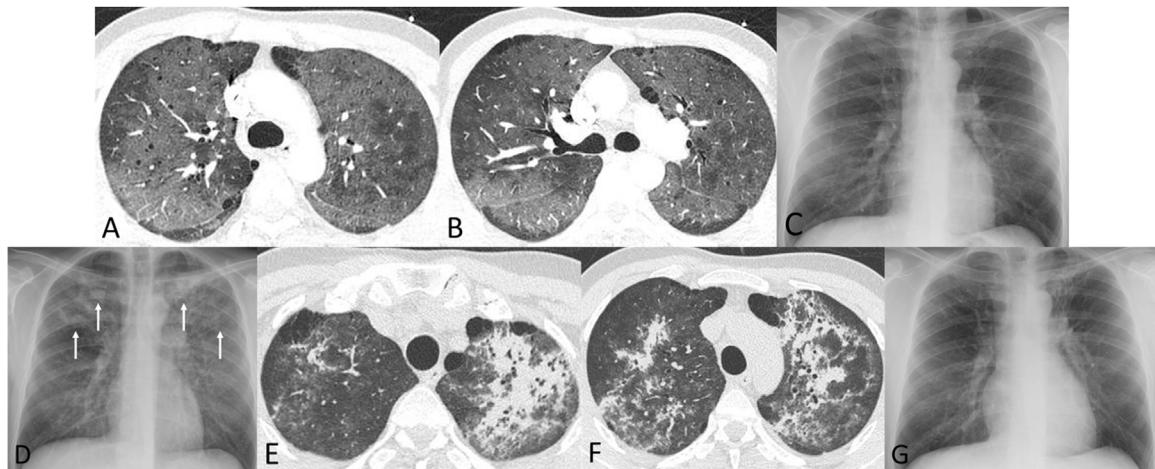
(A) and (B) Axial thoracic CT images (lung window) show extensive ground-glass opacities in both lungs, consistent with *Pneumocystis jirovecii* pneumonia. (C) Posteroanterior chest radiograph performed on the day of discharge shows resolution of opacities after treatment with cotrimoxazol and prednisolone. (D) Three days after being discharged, a repeat chest radiograph shows new-onset bilateral consolidations (arrows). (E) and (F) Axial thoracic CT images (lung window) show large peribronchial consolidations with bronchial lumen dilatation, a pattern typical of organizing pneumonia. (G) Posteroanterior chest radiograph performed one month after (D) shows an almost complete resolution of the pulmonary opacities.
